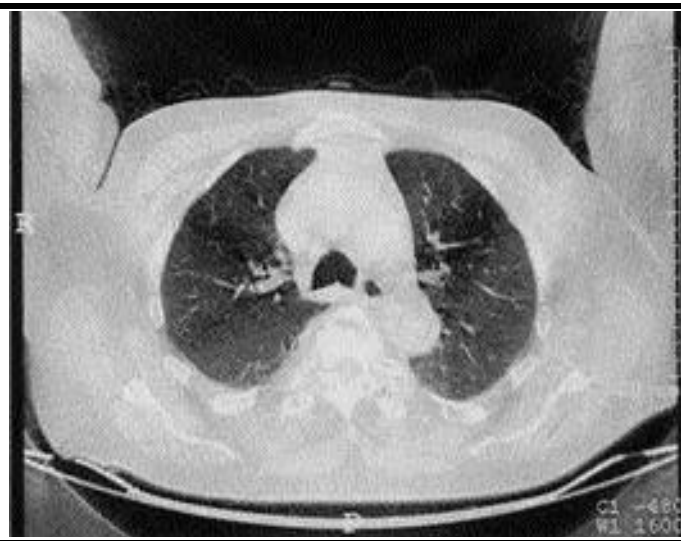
Ground glass appearance on HRCT.
